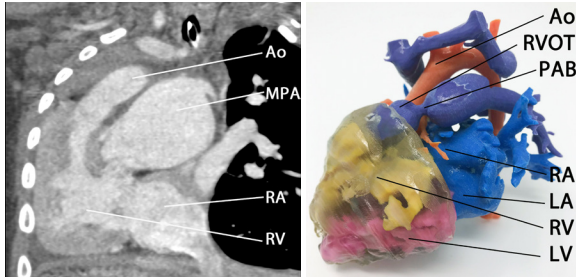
CT and 3D model of a 2-year-old with dextrocardia, double outlet right ventricle, atrioventricular canal, s/p pulmonary arterial banding and Glenn shunt (AO-Aorta, LA- left atrium, LV – left ventricle, MPA – main pulmonary artery, PAB – pulmonary artery band, RA – right atrium, RV – right ventricle, RVOT – right ventricular outflow tract).
